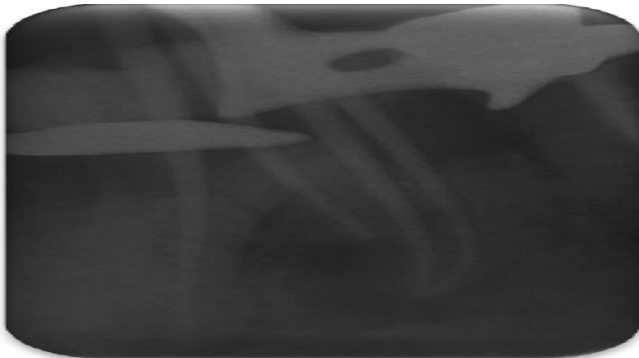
Radiography with masters gutta cones
